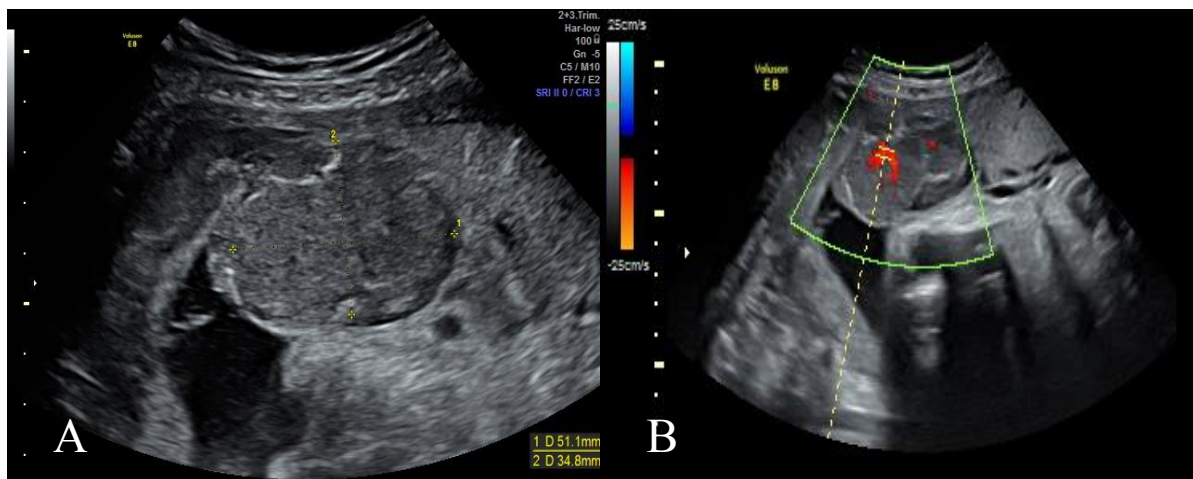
Gray-scale ultrasound image of well-demarcated large CA at gestational age 34+5 weeks (A); color Doppler image, same case (B).
